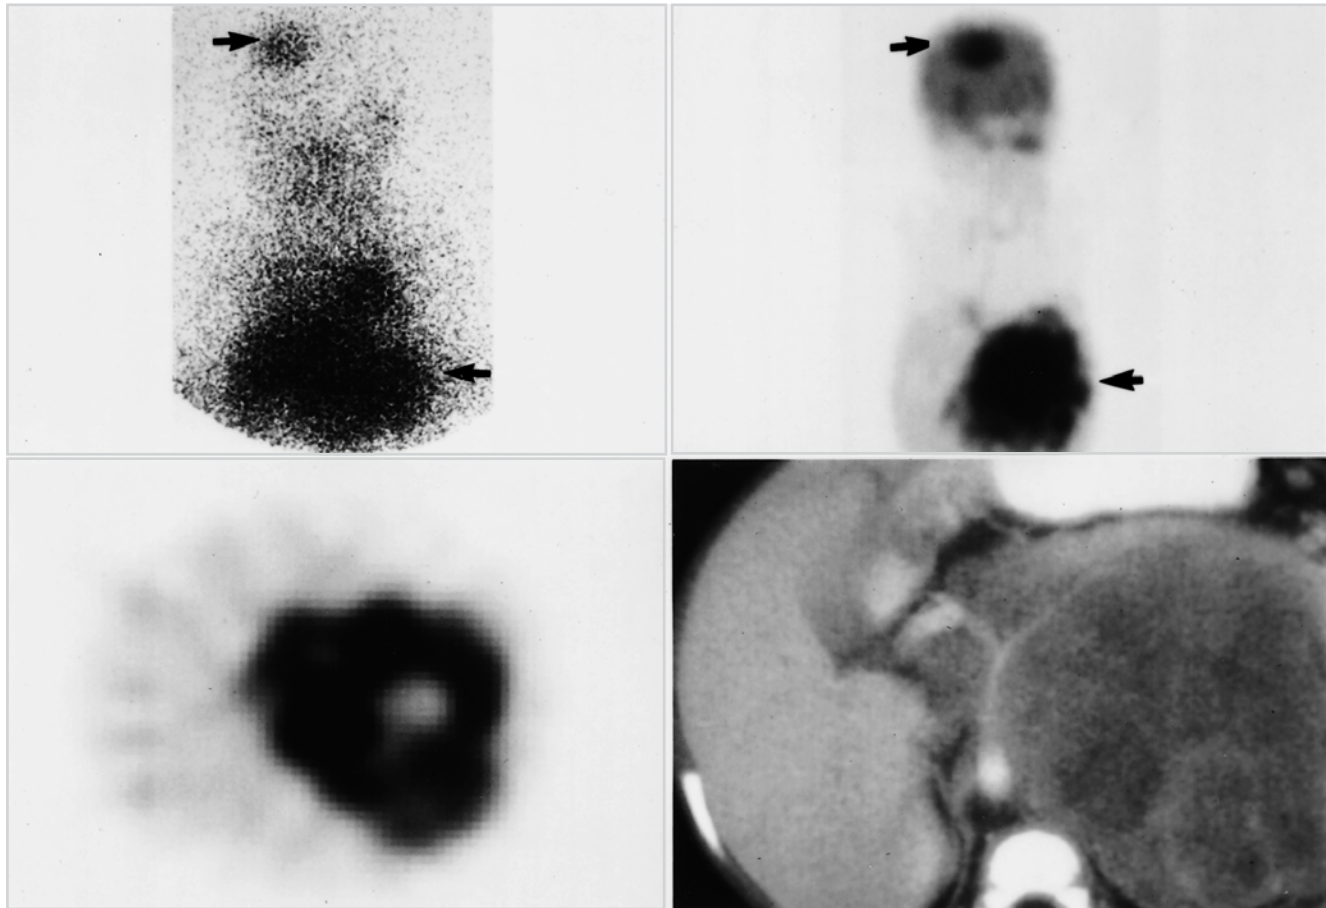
Images of a 2-year-old girl with neuroblastoma at presentation. *Top left:* Anterior planar view of the head, neck, chest, and upper abdomen 48 h following [^{131}I]MIBG injection. An area of abnormal uptake is present in the right superior aspect of the skull (*upper arrow*). A large focus of abnormal uptake in the primary tumor (*lower arrow*) extends from the upper left abdomen medially and inferior to the liver. *Top right:* Anterior projection of the head, neck, chest, and upper abdomen approximately 1 h following FDG injection. Increased FDG uptake in the skull (*upper arrow*) corresponding to the site of abnormal [^{131}I]MIBG uptake is well visualized against the normal brain uptake of FDG. Increased FDG uptake is present in the primary tumor (*lower arrow*). Note the paucity of background activity in the chest and abdomen. *Bottom left:* Transaxial image through the midabdomen shows marked FDG uptake in the primary tumor. A central area of decreased FDG accumulation probably represents necrosis. *Bottom right:* A large mass in the left abdomen is shown in a transaxial CT image. This set of images demonstrates that neuroblastomas are metabolically active. The primary tumor and metastases can be well visualized with FDG-PET. (Reprinted with permission from Jadvar H, Connolly LP, Shulkin BL, Treves ST, Fischman AJ. Positron-emission tomography in pediatrics. *Nuclear Medicine Annual* 2000;53–83.)
